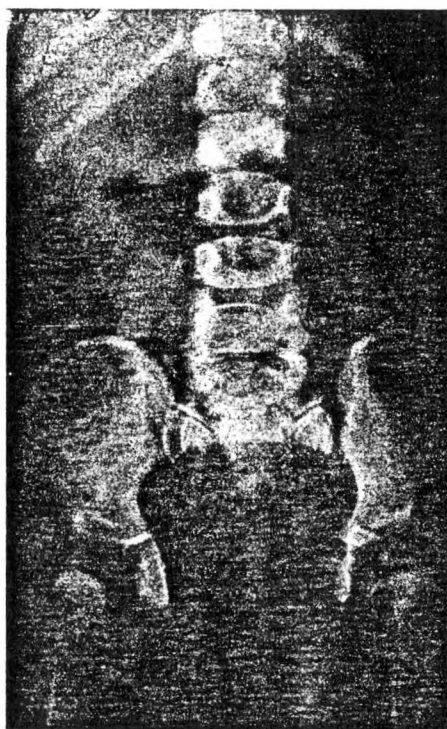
X-ray of the pelvis of a patient with chronic lead poisoning showing increased density of iliac crests and ischia. Also note the density of the distal end of the right twelfth rib.
